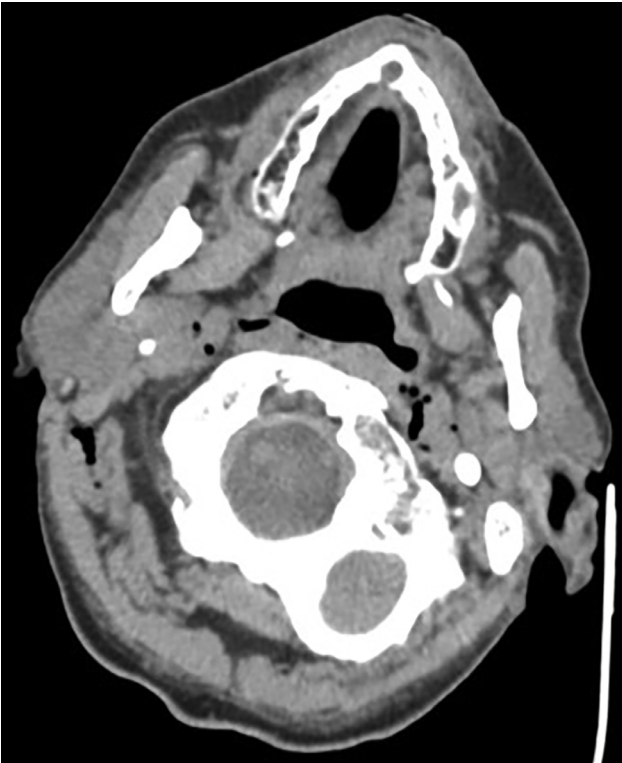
CT scan of the neck showing the bilateral presence of air within soft tissues around the carotid sheaths.
